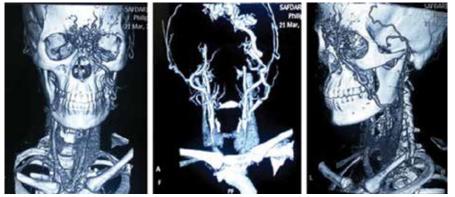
Post facial artery ligation a repeat CT angiography showed no change in size of AVM.
